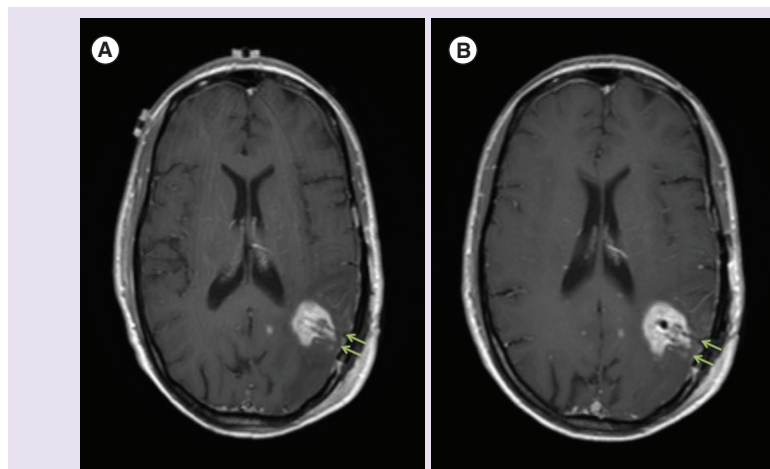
(A) MRI demonstrating convection-enhanced delivery catheter placement in a patient with recurrent glioblastoma. Two individual catheter tracts are visualized in a patient with recurrent GBM. (B) An additional representative axial MRI of catheter placement in the same patient.
